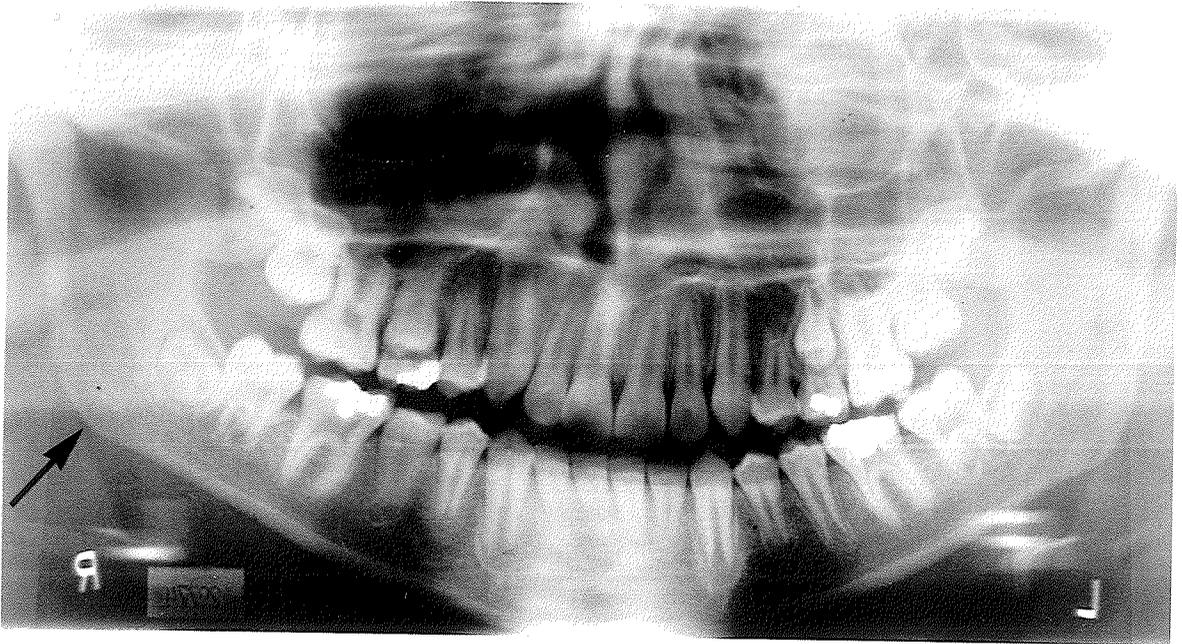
Panoramic Radiograph showing gonial angle
